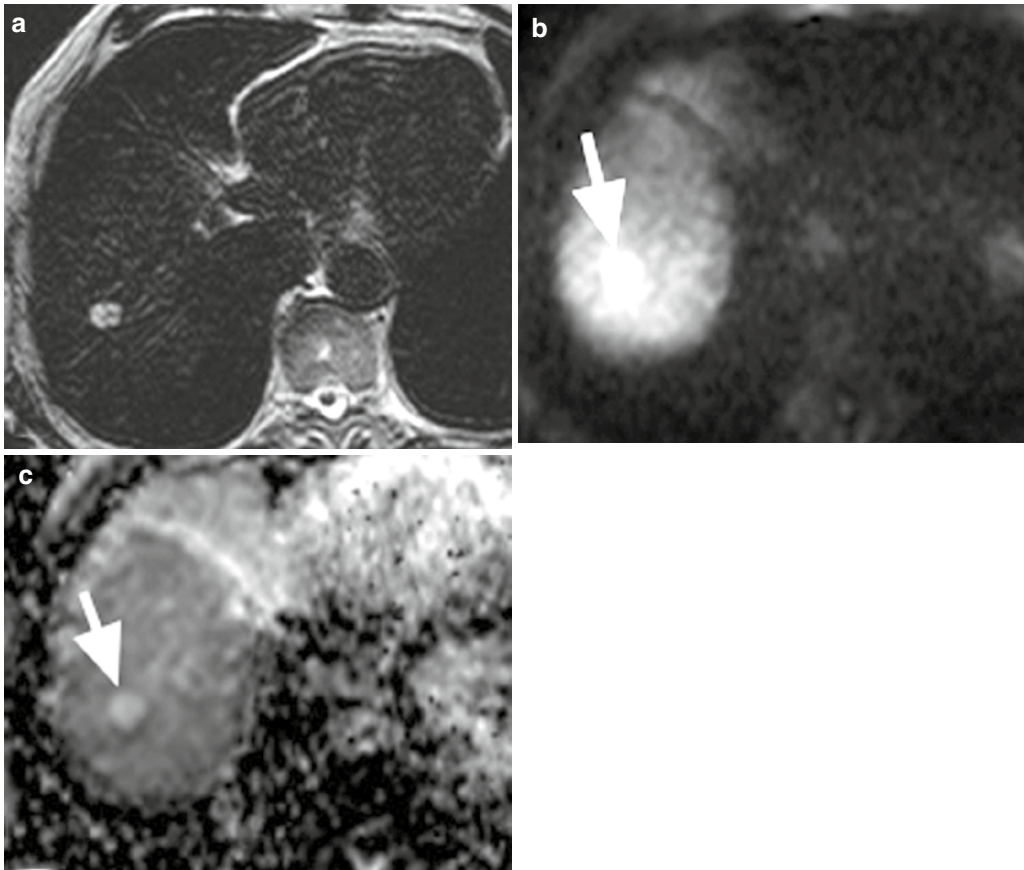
Mucinous metastasis to right lobe of liver from rectal cancer. (a) T2-weighted imaging at long echo time (TE=240 ms) shows hyperintense lesion (arrow) in right lobe of liver. (b) Lesion demonstrates T2-shine-through
